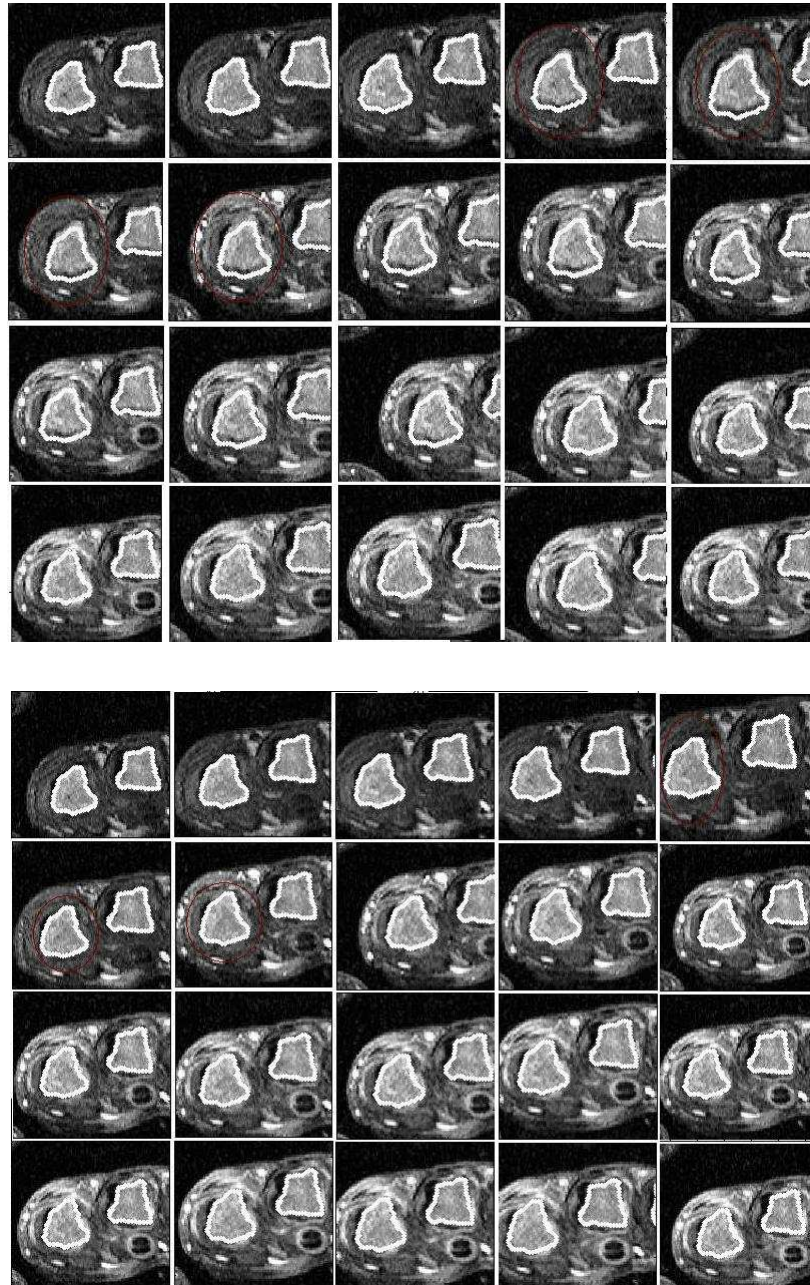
Magnified images from a DCE-MRI slice of the MCPJs acquired with the high field scanner before (top) and after (bottom) registration. The joints, detected in the target and superimposed on each image in the temporal slice, are shown in white. before registration, the location of the joints detected in the target does not coincide with the location of the joints in images 3, 4, 5, etc. After registration with  $W$ -transformation (bottom), the location of the joints detected in the target coincide with the location of the joints in images 3, 4, 5, etc.
